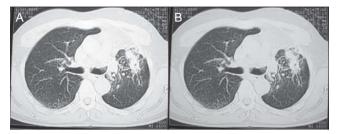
Chest computerized tomography (CT) after 5 months of treatment.
